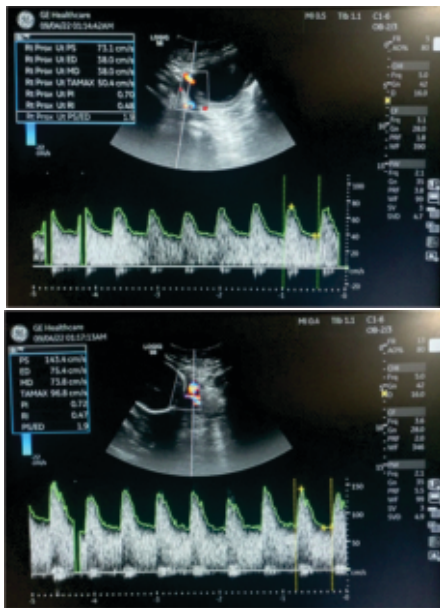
Right and Left uterine artery Doppler and pulse waveform of a diagnosed patient of preeclampsia at 25 weeks of gestation with absent pre-diastolic notch.
